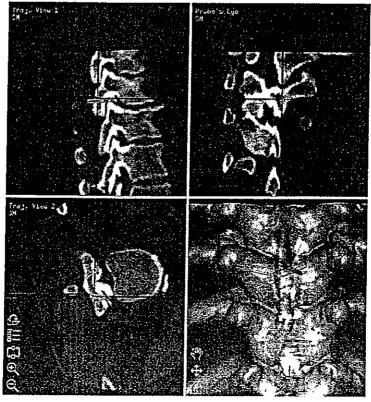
Images obtained using the real-time guidance system. The tip of the instrument (blue) shows the lateral margins of the area to be resected. The OLF (yellow) can be seen through the laminae on the 3D CT scan.
